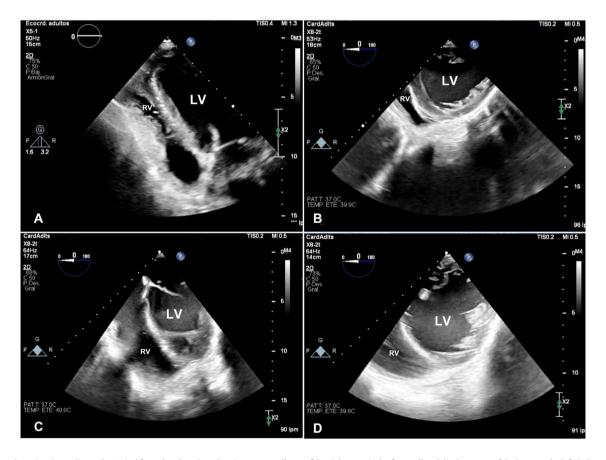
A: Transthoracic echocardiography. Apical four-chamber view showing severe collapse of the right ventricular free wall and displacement of the heart to the left. B: Transesophageal echocardiography (TEE). Deep transgastric view showing tethering of the right ventricular free wall and diastolic flattening of left ventricular anterior free wall. C: ETE. Mid-esophageal four-chamber view showing resolution of the right ventricular collapse and normal position of the heart at the center of the thorax. D: TEE. Deep transgastric view showing resolution of the tethering of the right ventricular free wall and diastolic flattening of left ventricular anterior free wall. RV: Right ventricle, LV: left ventricle.
